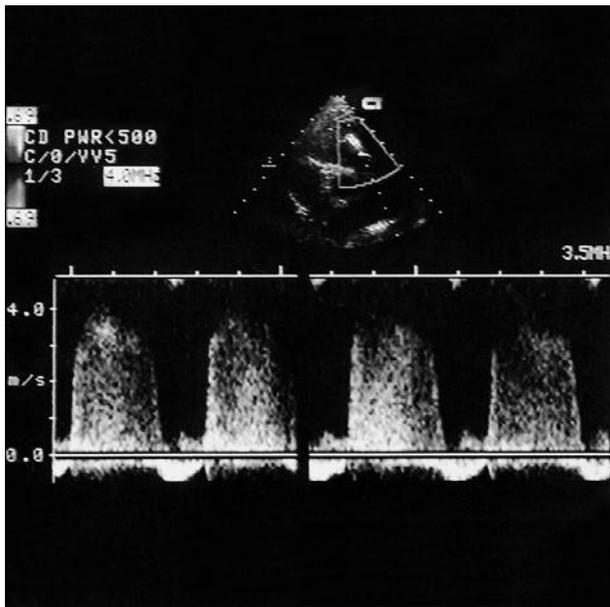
Color and continuous wave Doppler study demonstrated a mild degree of pulmonary regurgitation at a velocity of 4 m/sec, indicating high pulmonary arterial pressure.
